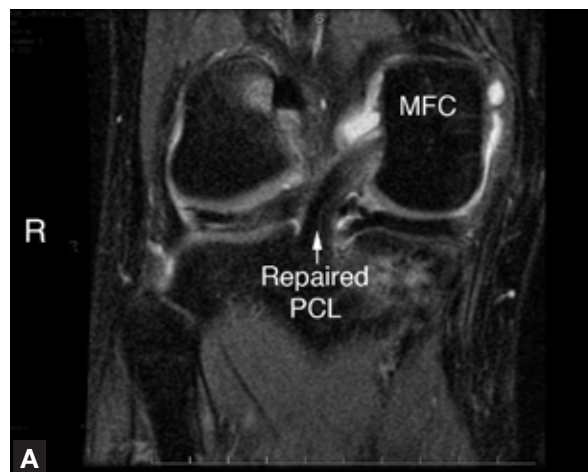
Postoperative coronal (A) and sagittal (B) magnetic resonance imaging of same patient 5 months after arthroscopic posterior cruciate ligament repair shows complete reconstitution of posterior cruciate ligament at its native insertion site.
